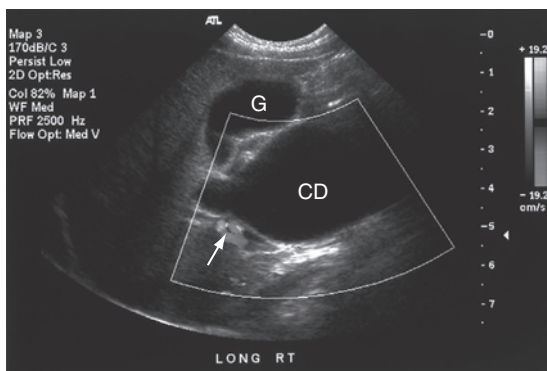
Choledochal cysts. A longitudinal sonogram demonstrates large choledochal cyst (CD) anterior to the portal vein (arrow). The gallbladder (G) is seen anterior to the choledochal cyst. No color Doppler flow was demonstrated within the cyst.
